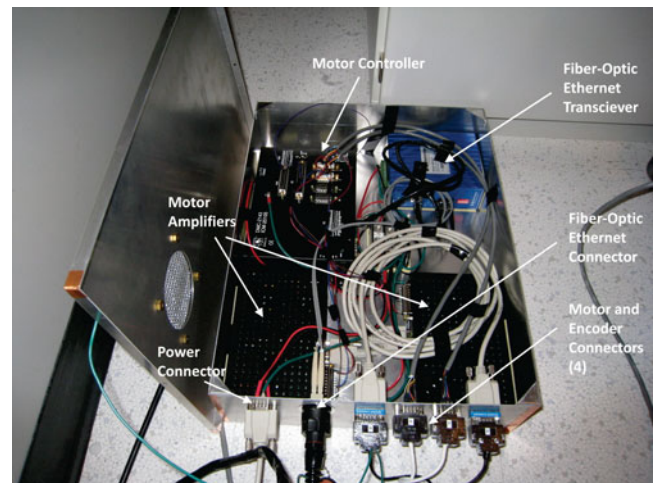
Photograph of the controller box designed to be placed inside the MRI scanner room near the control room wall waveguide that allows passage of electrical and fiber-optic cables. The box contains motor amplifiers, motion controller, and Ethernet media converter.
